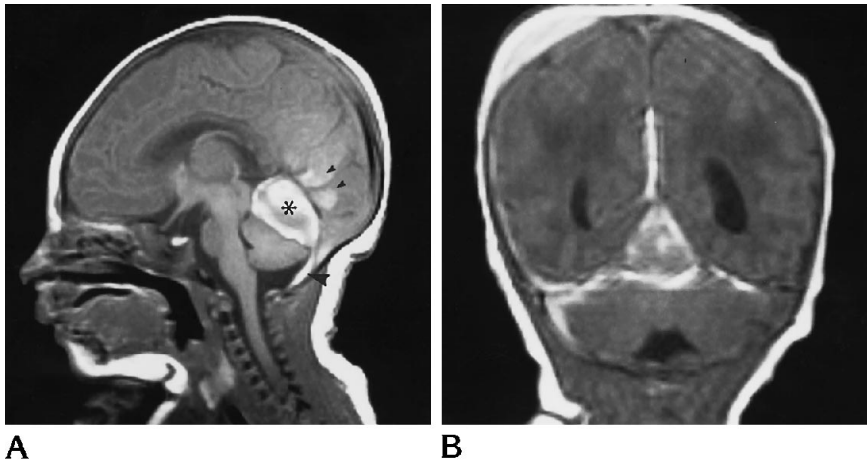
Case 2. A, Midsagittal T1-weighted image shows a large intracerebellar hemorrhage compressing the distal aqueduct of Sylvius and leading to noncommunicating hydrocephalus. Straight sinus (arrows) is slightly bowed dorsally and shows normal flow void indicating patency.
